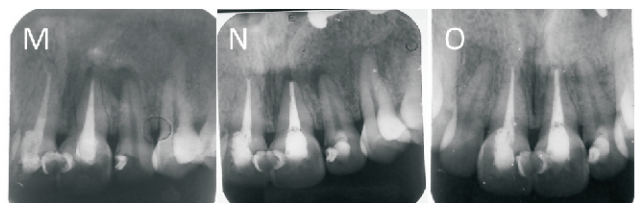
(M) Pre-treatment radiograph of the maxillary left lateral incisor showing a moderate periapical radiolucency at the apex. (N) Periapical radiographs obtained at the 6 months follow-up, shows evidence of healing after REPs. (O) Periapical radiograph obtained after 18 months, the periapical radiolucent lesion was completely healed. Tooth was asymptomatic and not responded to pulp sensibility tests.
